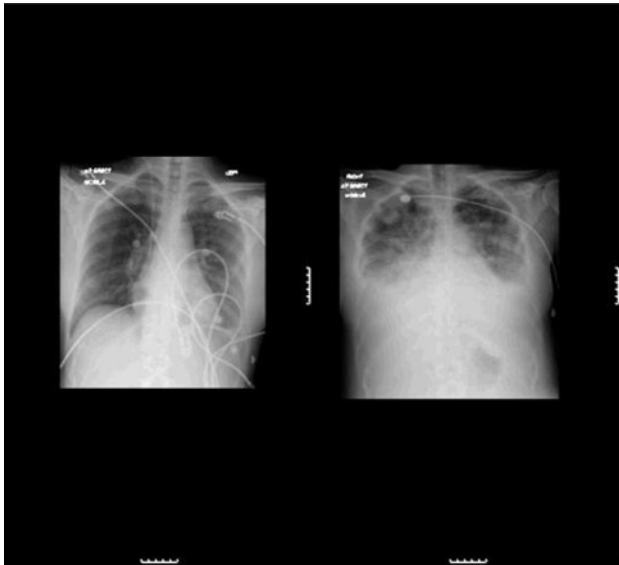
(a) Chest X-ray taken on first ICU discharge, 2 days prior to dialysis. (b) Chest X-ray taken post-dialysis showing gross pulmonary oedema.
